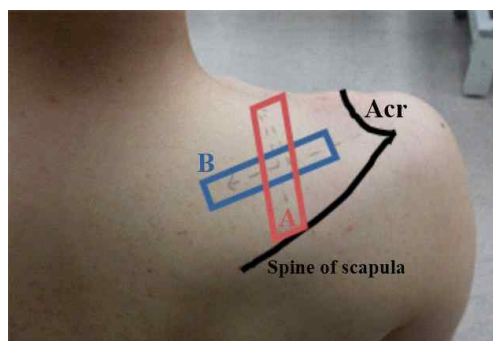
Ultrasound probe positioning (right shoulder in the resting position, Acr: acromion; A: sagittal ultrasound probe positioning for the MT images; B: longitudinal panoramic ultrasound probe positioning for the PA and FBL images).
